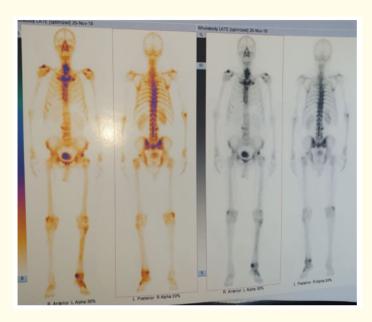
99mTc bone scintigraphy showing no sign of anormal uptake.
